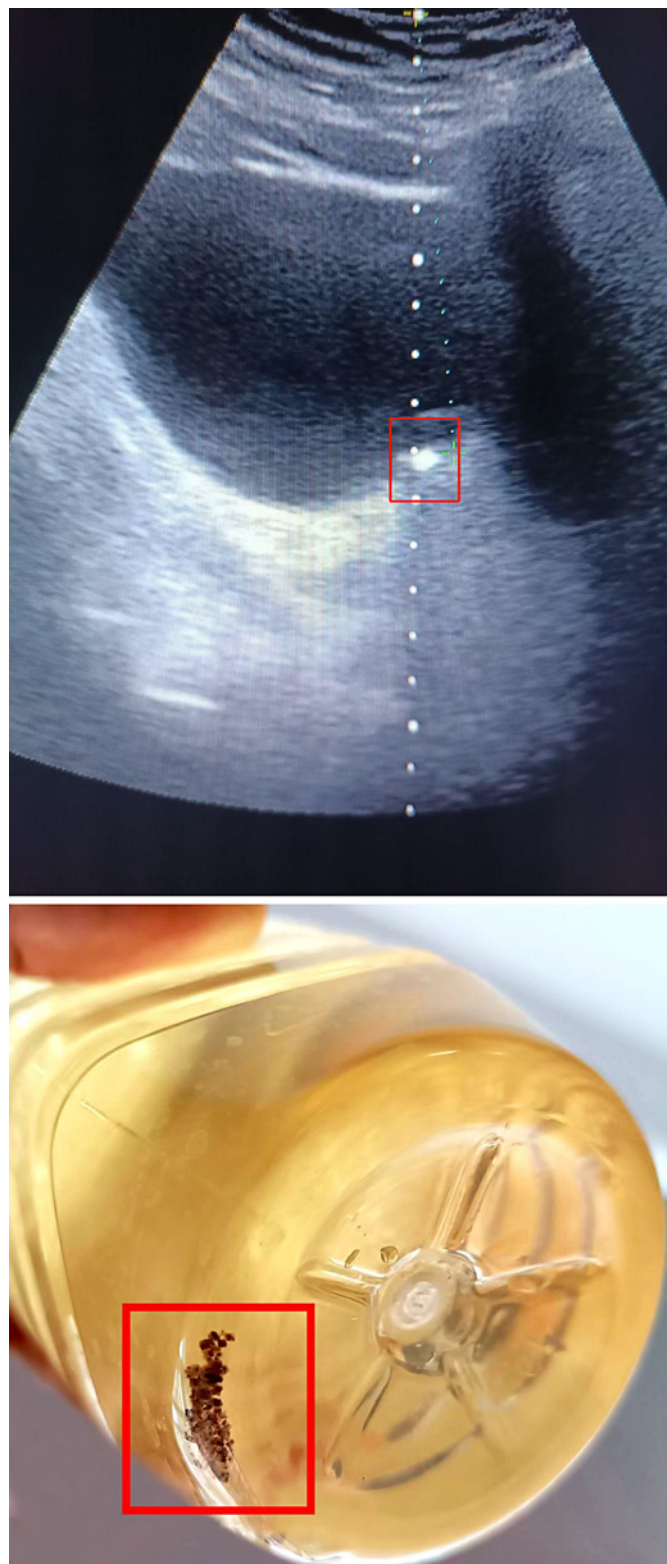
The image above is the stone under ultrasound localization; the image below is a stone passed in the urine after EVPL.
